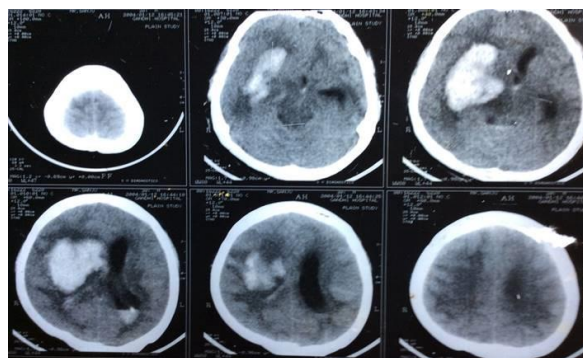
CT Scan Brain Plain revealed Cerebral Hemorrhage in Right capsulo ganglionic region with perilesional edema, with extension into lateral ventricle.
